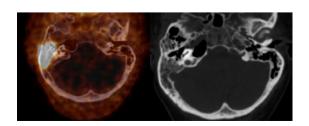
Mastoid cells on the right side without the corresponding pneumatization, showing occupancy by tissue of intermediate hypercaptant density that reaches SUV max 9.4.
